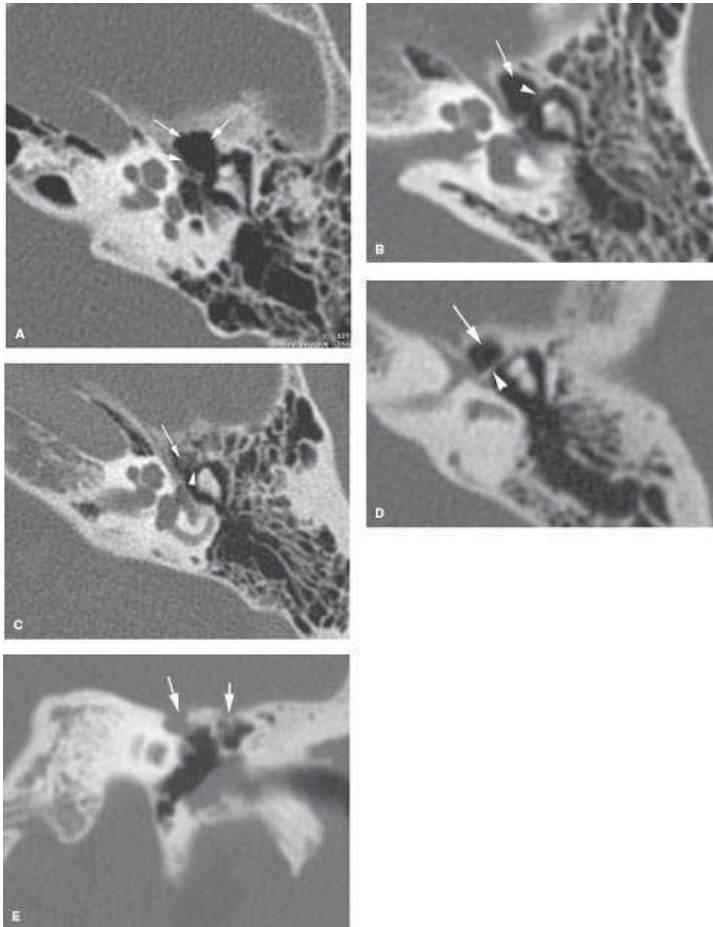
A–D: Anterior epitympanic recess (*arrows*). On axial computed tomography (CT) images, it is well seen that the recess differs in size. The recess may be separated from the epitympanum by a fibrous or bony septum (*arrowheads*). E: Dehiscence of the tegmen tympani (*arrows*) is common in the area of the anterior epitympanic recess and first genu of the facial nerve. The coronal CT image shows dehiscence of the tegmen in that area caused by arachnoid granulations.
